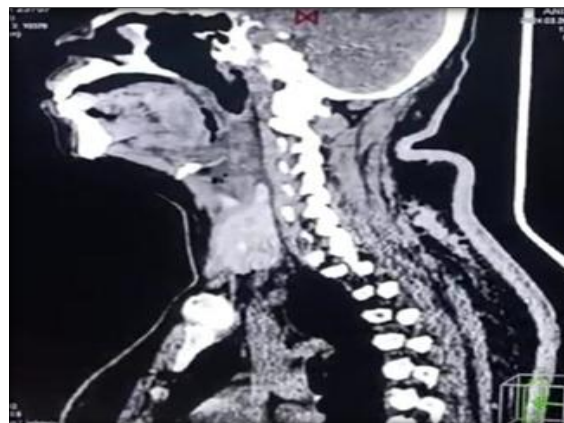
Sagittal CT scan of neck showing DNSIs
